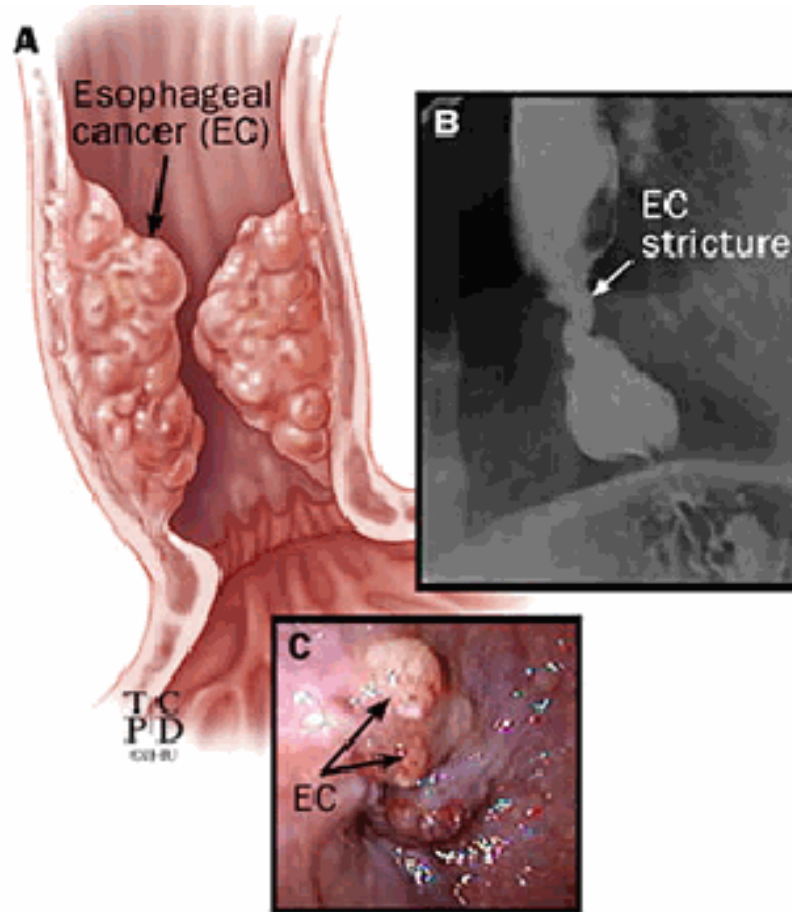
Esophageal cancer (A) with corresponding barium swallow x-ray (B) and endoscopic view (C).
